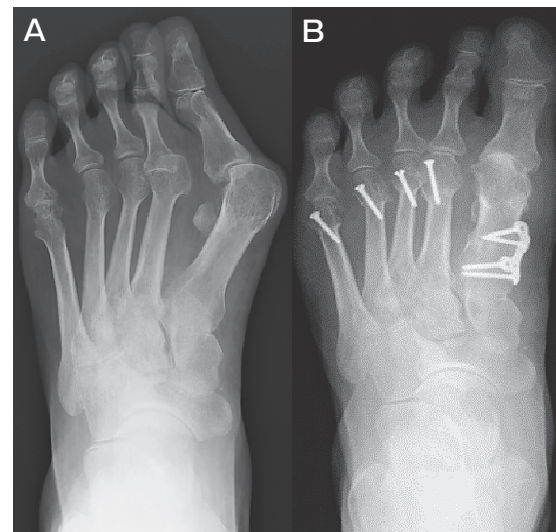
Radiographs showing before (A) and after shortening oblique osteotomy for lesser metatarsal bone with screw fixation (B). For the 1st metatarsal bone, correction osteotomy and plate fixation was done.
